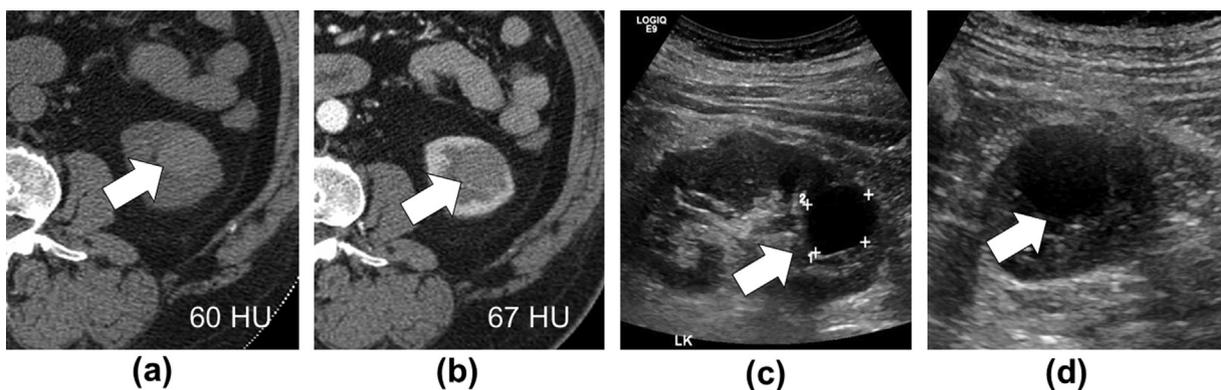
A 76-year-old woman with incidentally detected right renal mass on unenhanced CT performed for renal colic. (a) Axial unenhanced CT image shows a homogeneously hyperattenuating nodule with an attenuation value of 60 HU. A dedicated renal protocol CT was suggested to further characterise. (b) Axial contrast-enhanced CT image obtained during the nephrographic phase shows no enhancement (increase to 67 HU). (c) Sagittal and (d) transverse grey-scale ultrasound images performed prior to CT, but not reviewed at the time of the CT recommendation or protocolling, confirm the hyperattenuating nodule as an anechoic simple cyst with an imperceptible wall and increased through transmission features, which are diagnostic of a Bosniak type I cyst requiring no further management or imaging follow-up (white arrows).
